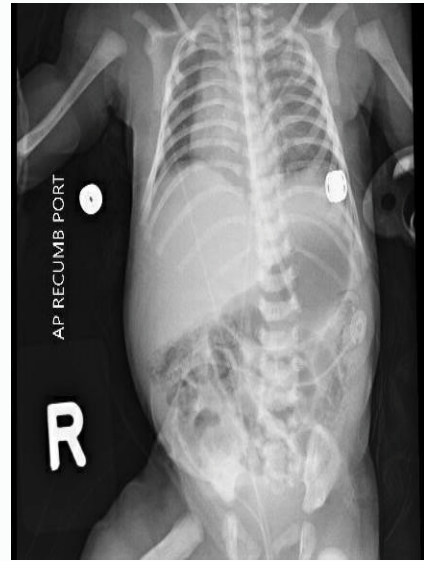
Abdominal radiographic findings of pneumatosis intestinalis.
